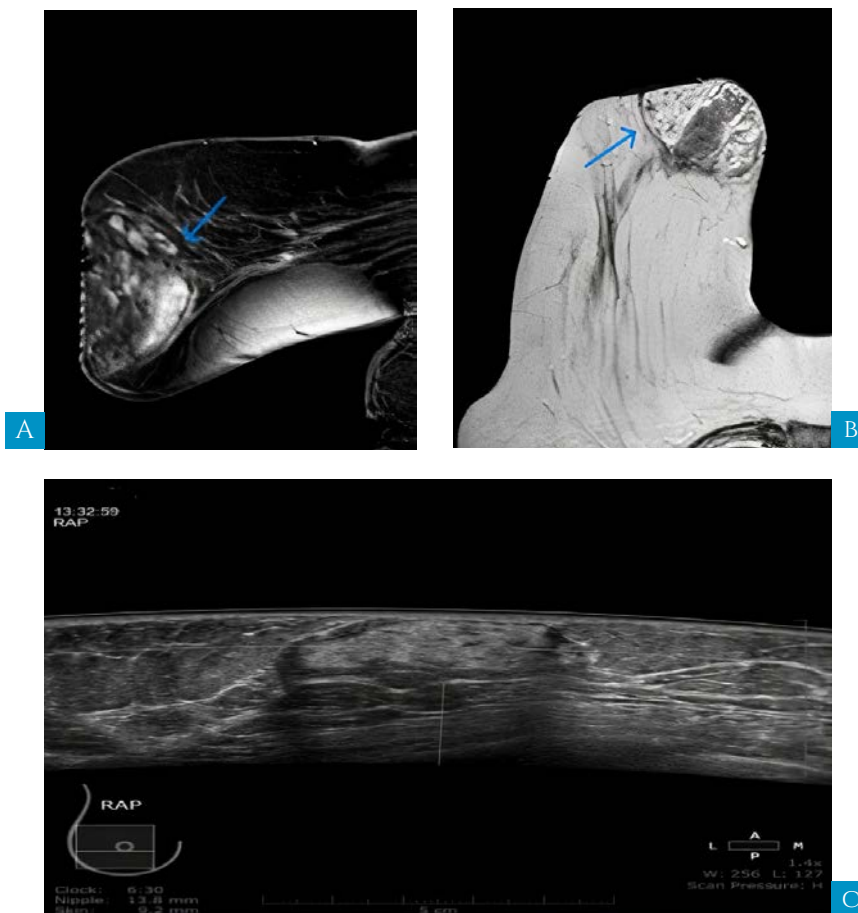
49-year-old female patient presenting to us by a clinically palpable right retro areolar breast lump A. MRI Post contrast with fat sat image sagittal view of the right breast. B. MRI T1 weight image axial view of the right breast. A&B show encapsulated mass with heterogeneous signal intensity within confirmed to the fatty and fibro glandular element and the fibro glandular element exhibited contrast enhancement similar to normal glandular tissue (BIRADS II). C: Automated ultrasound right AP axial image shows oval shape mass with circumscribed margins, parallel orientation and heterogeneous echo pattern (BIRADS II).
